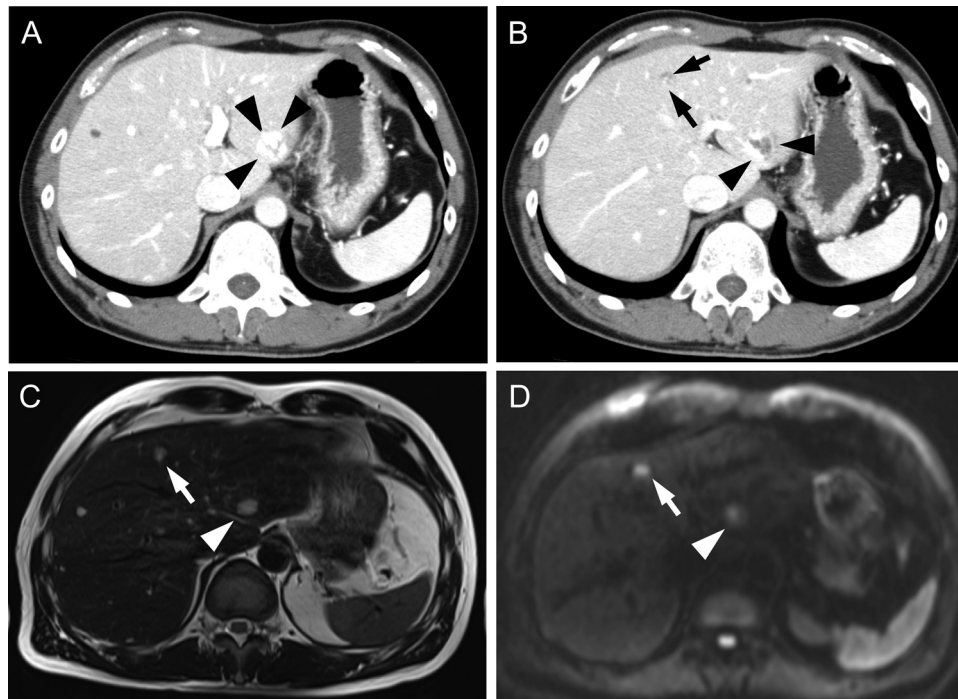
Preoperative contrast-enhanced abdominal computed tomography (A, B) and magnetic resonance imaging (C, D) of the donor liver with cavernous hemangiomas. S2 hemangioma was indicated by arrowheads, and S4 hemangioma was indicated by arrows.
